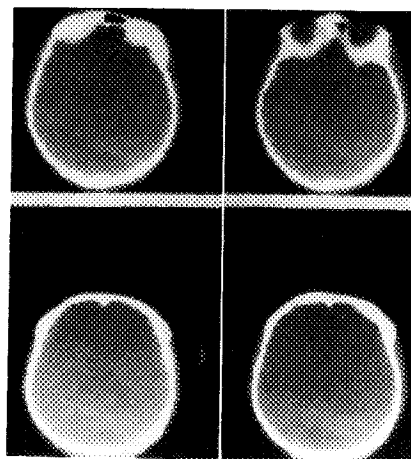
Computed tomographic scan of skull confirms findings described in Fig. 2.
